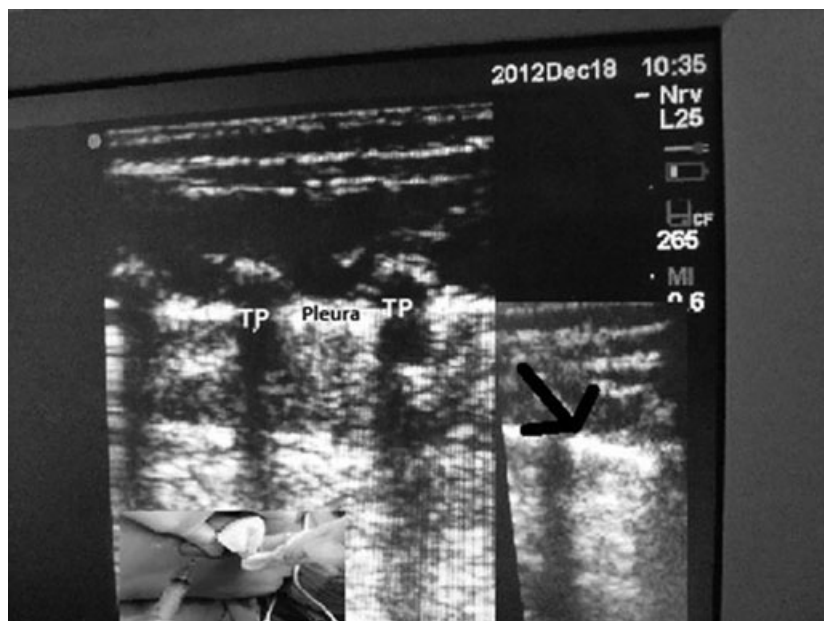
Ultrasound-guided paravertebral block in an 'out-of-plane' technique.
